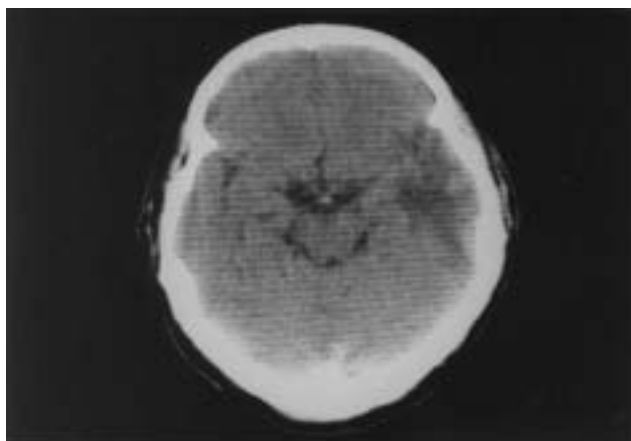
Axial view of brain CT in 1996 revealed finger-like hypodensity over the left temporal lobe.
